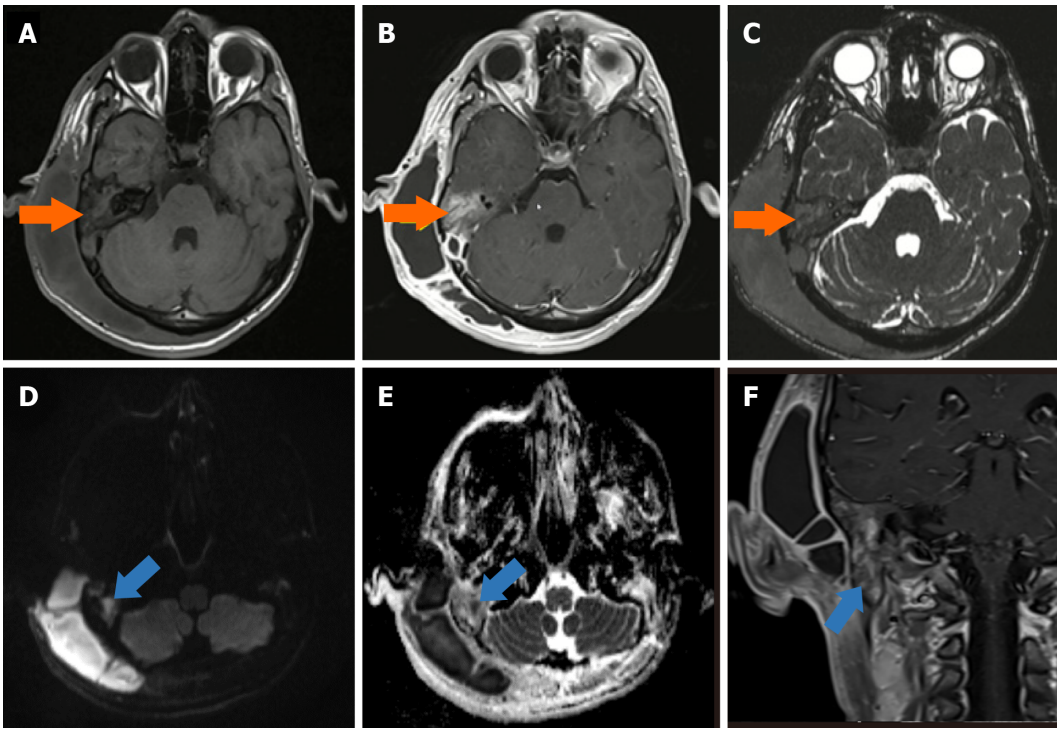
Otomastoiditis and accompanying cholesteatoma. A: The axial pre-contrast T1W; B: Post-contrast T1W; C: 3D-constructive interference in a steady state MR images show hyper-enhanced inflammatory alterations in the mastoid cells and middle ear on the right side (orange arrows); D: The axial diffusion-weighted; E: Apparent diffusion coefficient map; F: Coronal post-contrast T1W magnetic resonance images show the presence of cholesteatoma in the right inferior mastoid cells, which was not enhanced, but had significant diffusion restriction (blue arrows).
